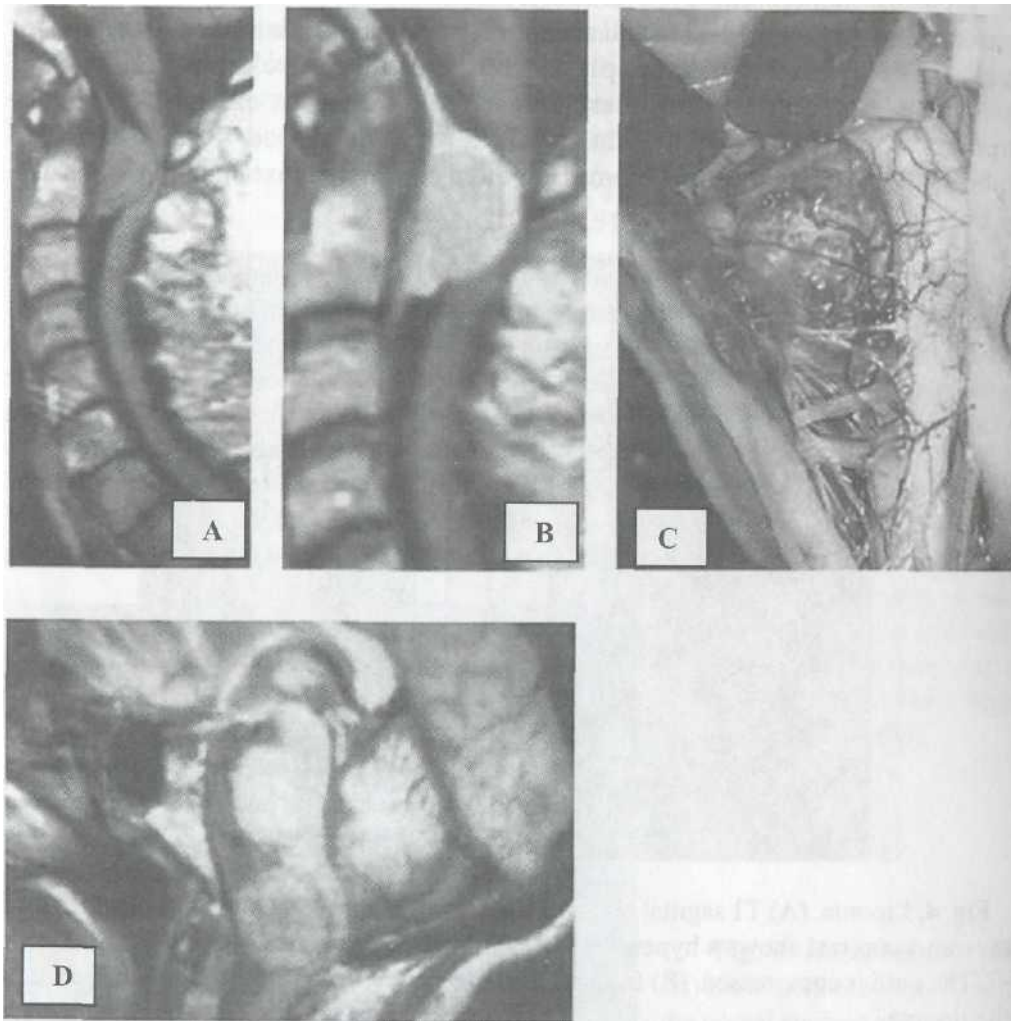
Meningioma. Pre- (A) and post-contrast (B) sagittal magnetic resonance images (MRI) of the cervical spine demonstrate a homogeneously enhancing, ventral and extraaxial tumor at C1-2. A clear dural tail is evident at the superior aspect of the lesion. Precontrast T1 sagittal MRI (C) and intraoperative photograph after posterolateral exposure (D) show a foramen magnum meningioma. The surface of the tumor is irregularly lobulated and displays moderate neovascularity (D).
